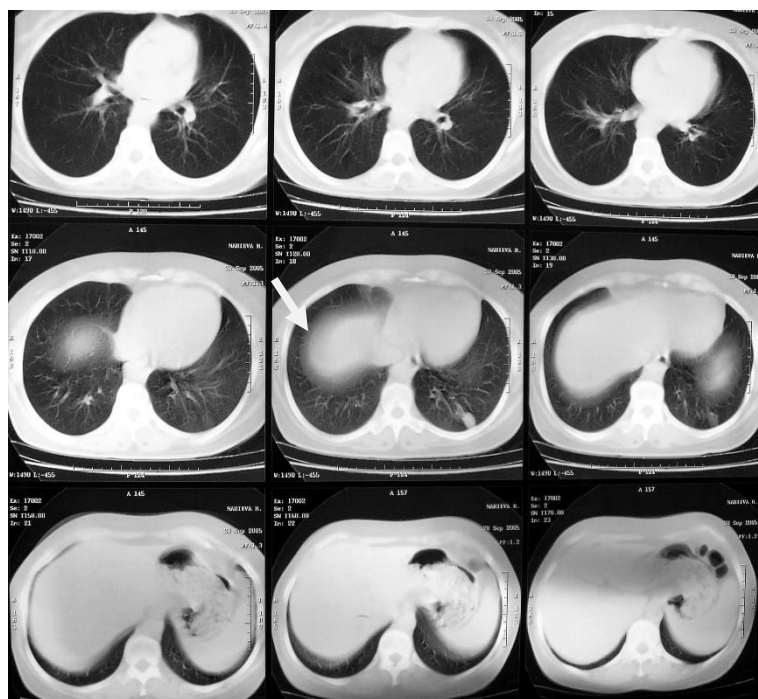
Computed tomography of the chest "hydatid sand" in echinococcal cyst modification echinococcus veterinorum.
